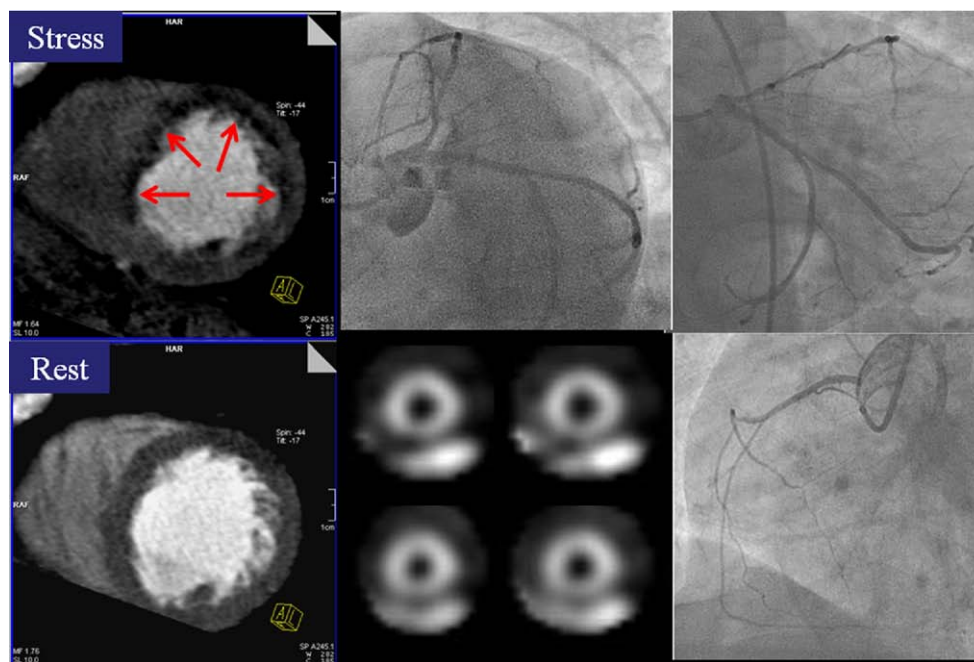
Example of CT Perfusion Identifying Multivessel Disease
